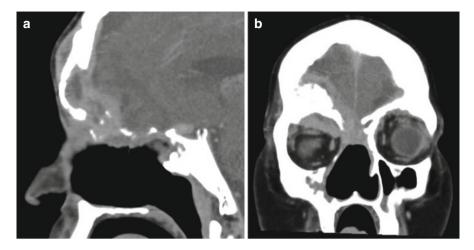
(a) (sagittal CT) and (b) (coronal CT): Recurrent olfactory neuroblastoma involving frontal sinus and dura 10 years after craniofacial resection
